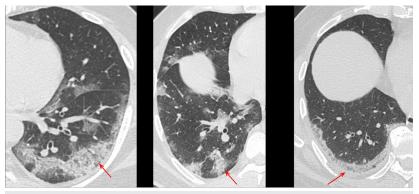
CT scan signs of Covid-19 - organizing pneumonia patterns. Axial images in 3 different patients show peribronchovascular and subpleural patterns.
